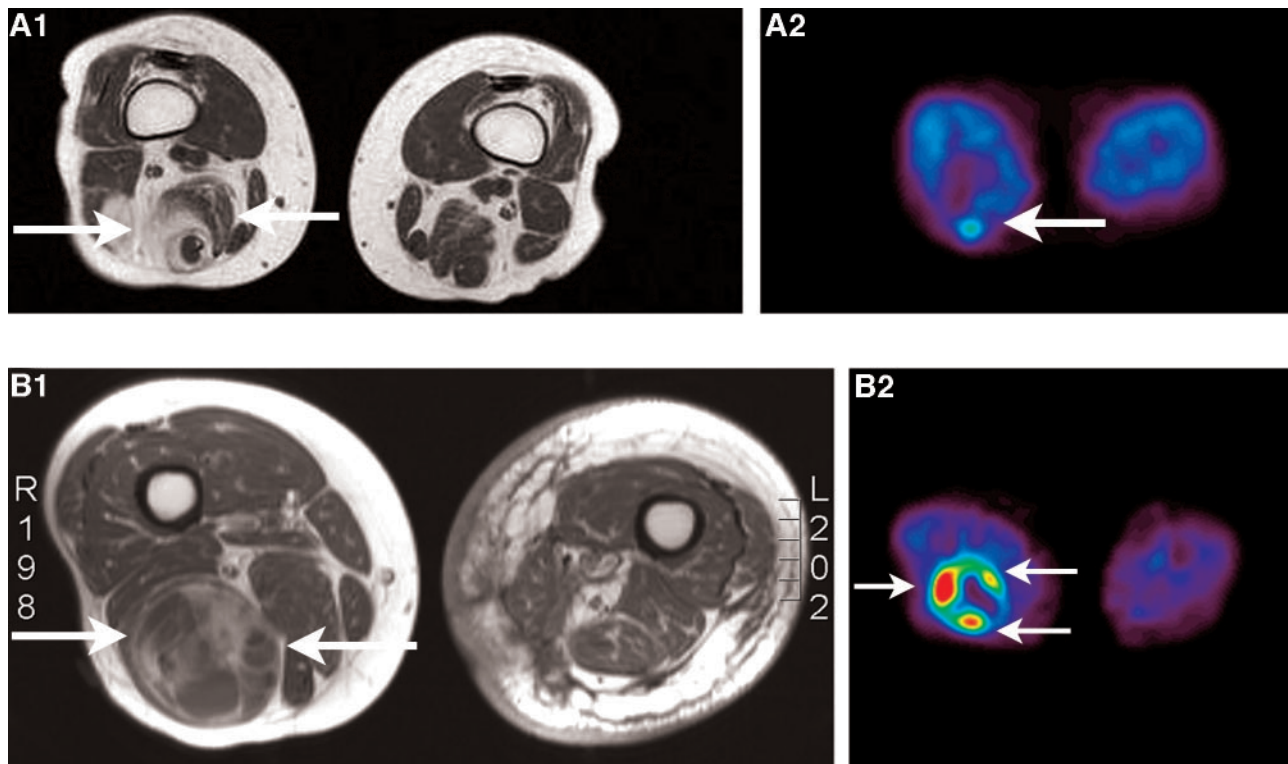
A, the magnetic resonance imaging (MRI; A1) and  $3'$ - $[^{18}\text{F}]$ fluoro- $3'$ -deoxy-L-thymidine-positron emission tomography (FLT-PET; A2) images of a low-grade soft tissue sarcoma (STS; patient 6); B, the MRI (B1) and FLT-PET (B2) images of a high-grade STS (patient 13). The MRI images of both patients demonstrate a heterogeneous tumor. However, the FLT uptake in the high-grade STS is higher than in the low-grade STS.
